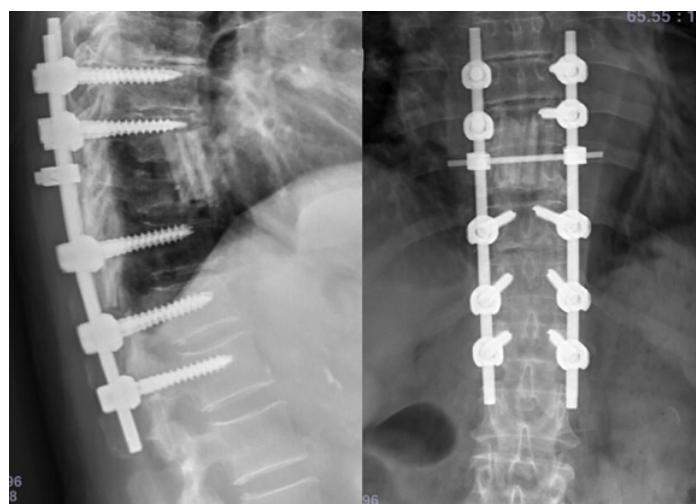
Final spinal construct. Postoperative anteroposterior and lateral radiographs demonstrating restored sagittal and coronal alignment.
